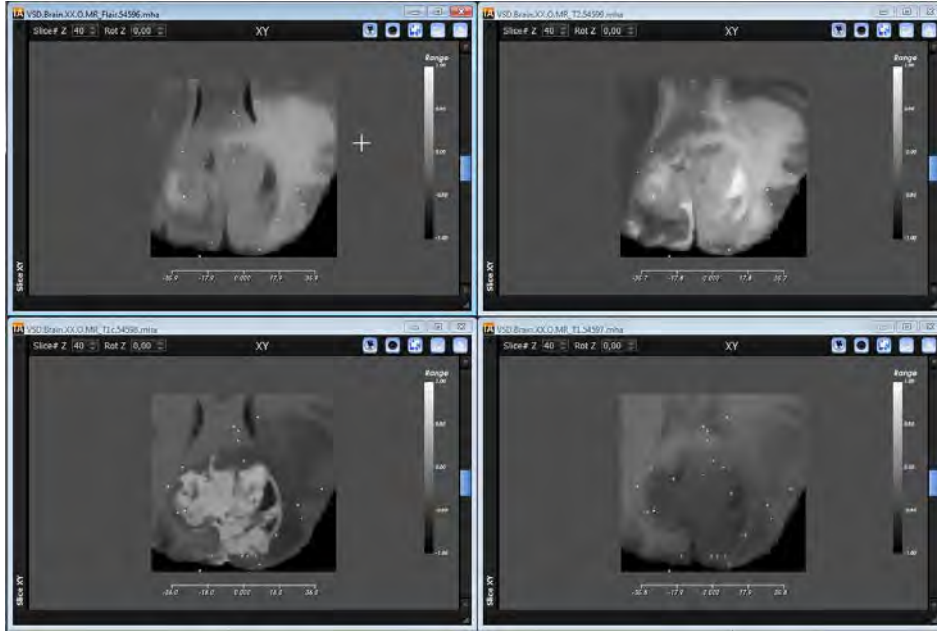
The four images show the MRI modalities used as input data sets to the SVM model and the selected seeds: green for label 0, yellow for label 1, violet for label 2, red for label 3 and blue for label 4.
